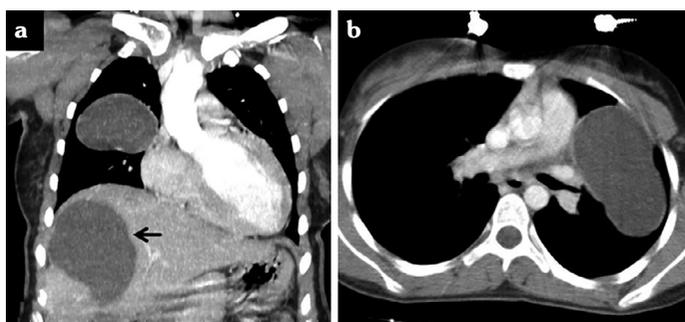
Computed tomography images of 2 patients with intact hydatid cyst. (a) Coronal thoracoabdominal images of a 29-year-old woman show non-ruptured cysts in the right lung and liver (arrow). (b) A cystic lesion with well-circumscribed fluid attenuation, homogeneous content, and smooth, hyperdense walls in the left lung of axial chest CT images of a 37-year-old woman
